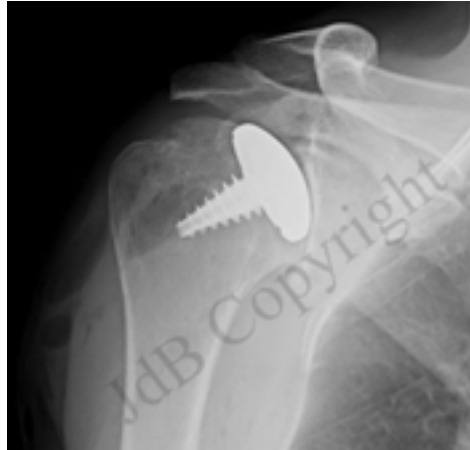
X-ray appearance of a Hemi-Cap having been fixed into the humeral head (ball of the joint)
